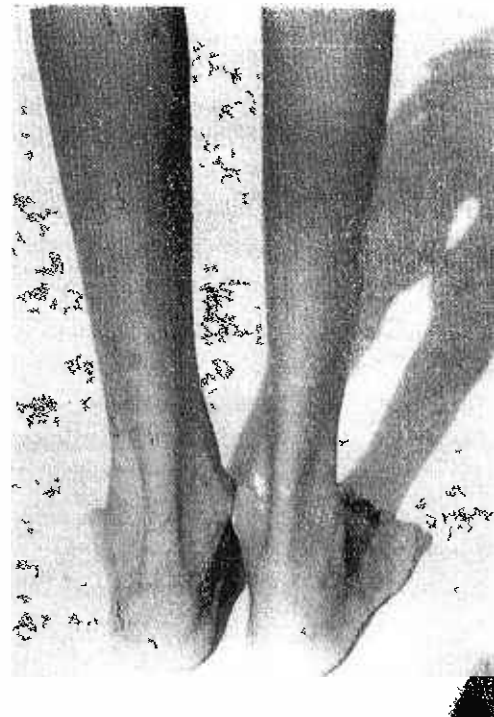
Clinical photograph of the patient whose X-ray of the right foot was seen in Fig. 1. There is good correction of the deformity after Grice's operation and transfer of the peroneous longus tendon.
